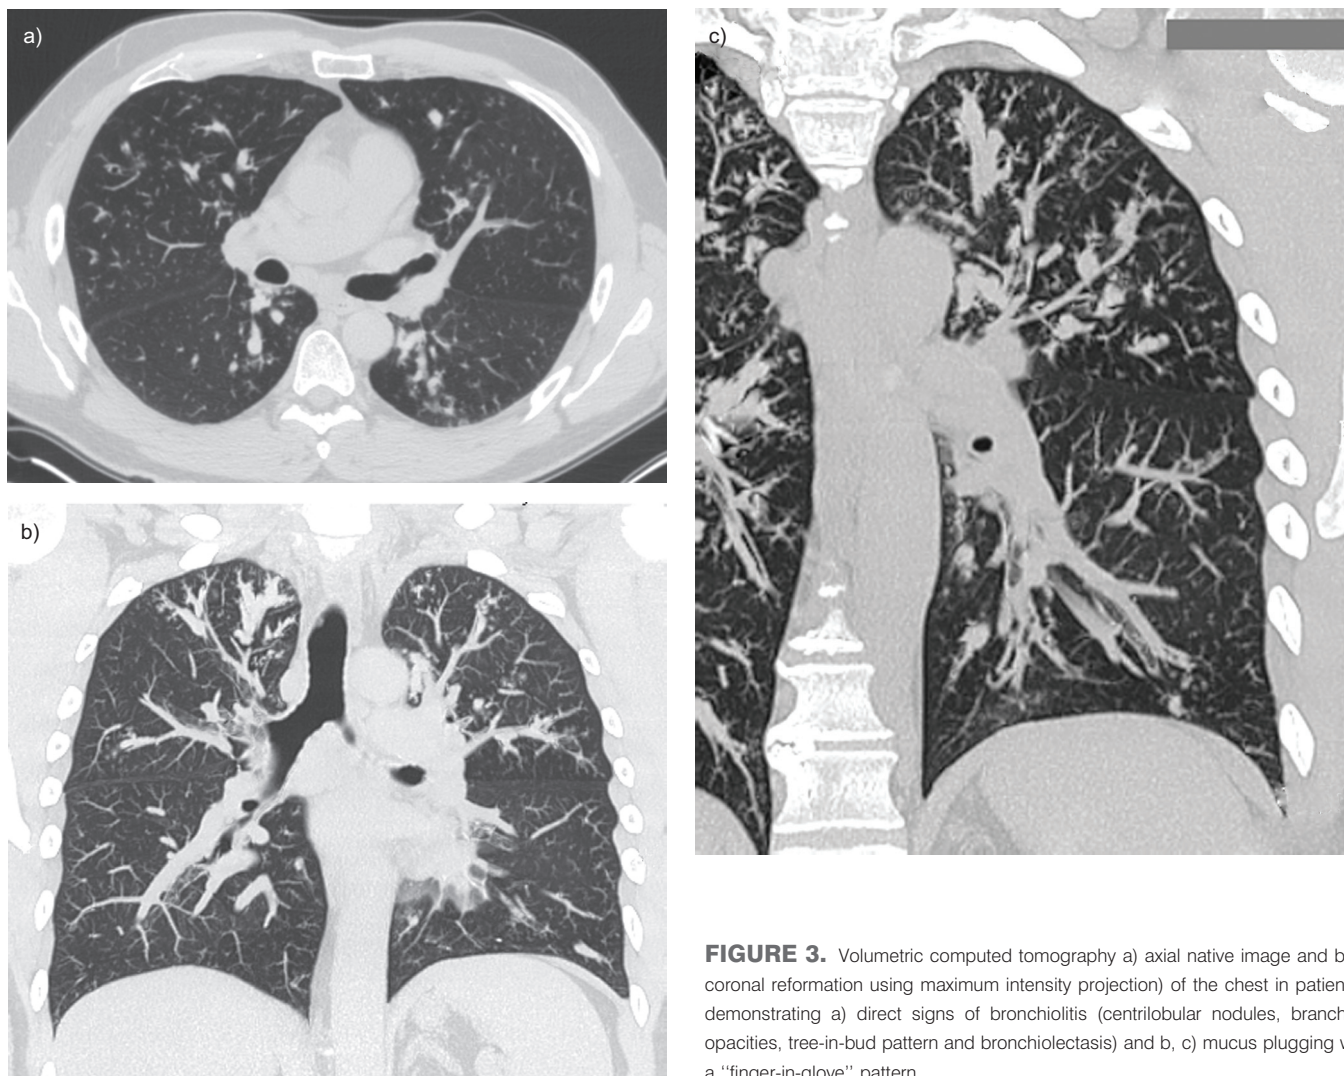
Volumetric computed tomography a) axial native image and b, c) coronal reformation using maximum intensity projection) of the chest in patient 3, demonstrating a) direct signs of bronchiolitis (centrilobular nodules, branching opacities, tree-in-bud pattern and bronchiolectasis) and b, c) mucus plugging with a "finger-in-glove" pattern.
